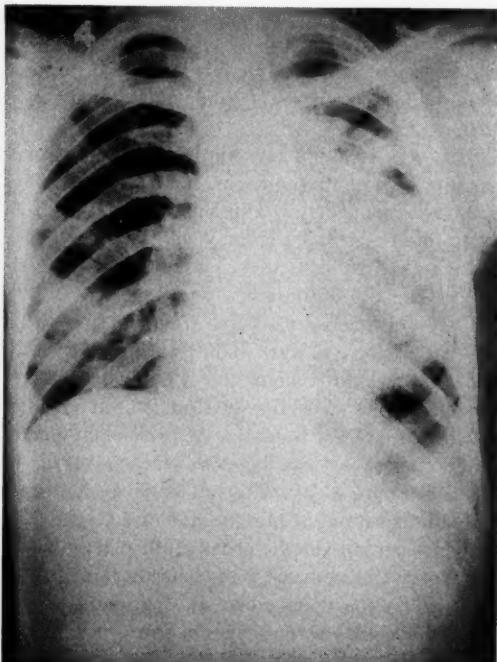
X-ray of same patient as in Fig. 4 at three months of treatment.
